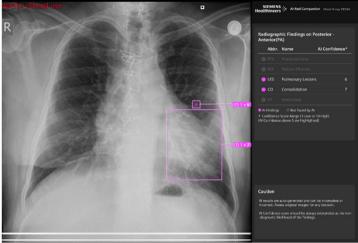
Example of an AI-generated chest X-ray report with markings indicating the pathological findings with the AI confidence scores.
